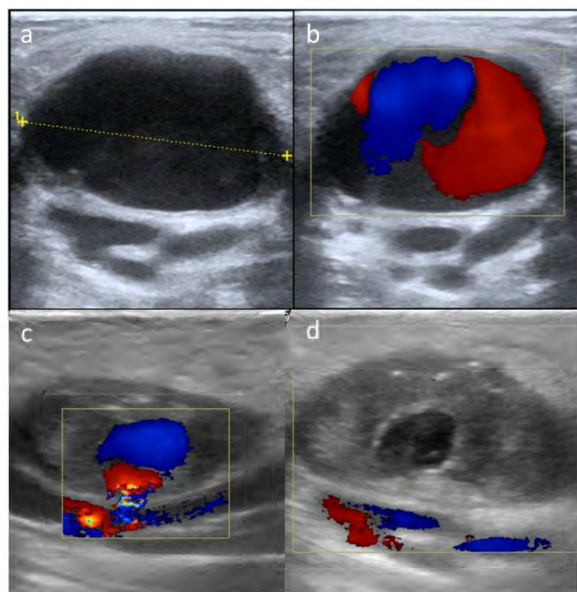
a and b. Gray scale (a) and Color Doppler Images (b) of the common femoral artery pseudoaneurysm at presentation. c. Color Doppler US image of the lesion posttreatment demonstrating residual flow at the center with thrombosed periphery. d. Follow-up imaging next day showing no flow within the pseudoaneurysm sac.
